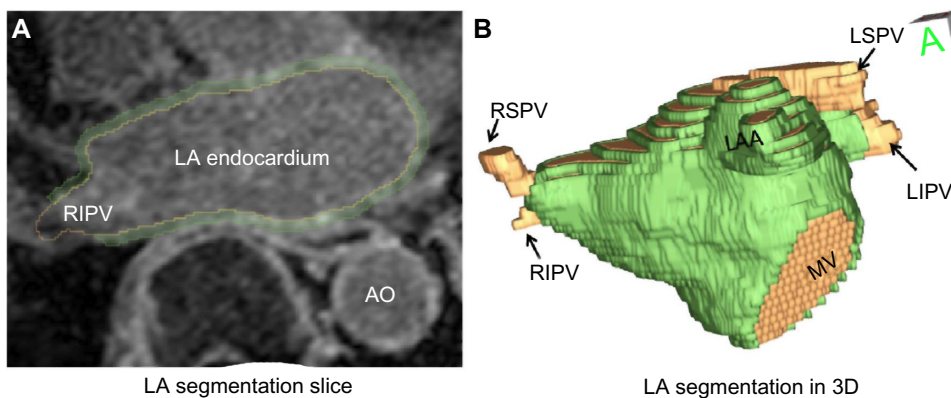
An example of LA segmentation from the MRA and LGE-MRI. (A) A single slice from a segmentation of the LA wall (LGE-MRI). (B) A surface rendering of the LA segmentation, showing attached PVs, MV, and the LAA.
